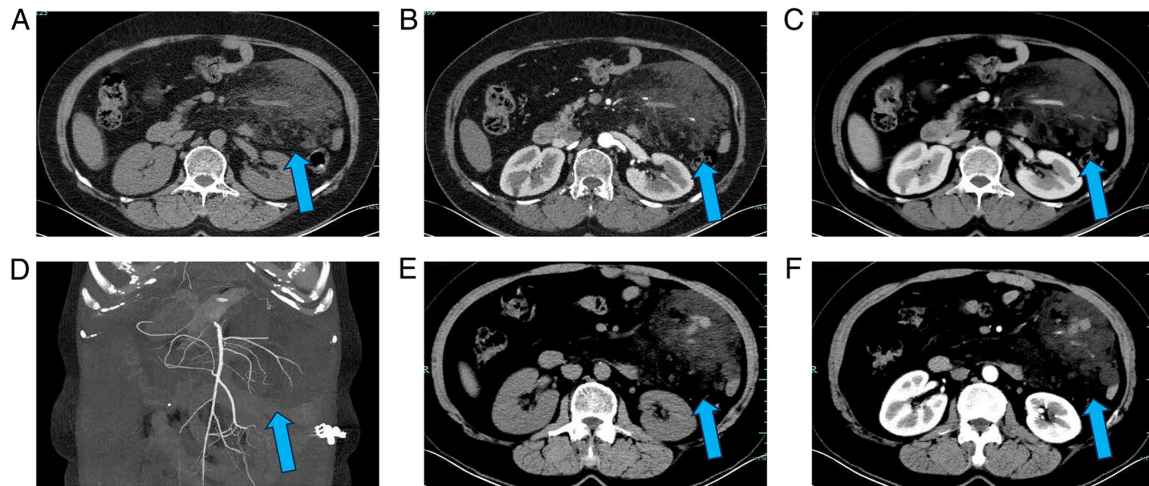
Serial contrast-enhanced CT findings of mesenteric cavernous lymphangioma. (A-D) Initial CT examination performed at admission. (A) Non-enhanced CT image demonstrating an irregular, well-defined, low-attenuation mass in the left middle abdomen (blue arrow). (B) Arterial phase CT image showing no notable enhancement of the lesion, with mesenteric vessels traversing through the mass (blue arrow). (C) Portal venous phase CT image demonstrating persistent absence of significant enhancement within the lesion, with preservation of the traversing mesenteric vessels (blue arrow). (D) MIP reconstruction image demonstrating the vessels passing through the lesion (blue arrow). (E and F) Follow-up contrast-enhanced CT performed 7 days after admission. (E) Non-enhanced CT image showing newly developed hyperattenuating foci within the lesion, suggesting intralesional hemorrhage (blue arrow). (F) Contrast-enhanced CT image demonstrating persistent absence of notable enhancement within the lesion, with the hemorrhagic components remaining visible (blue arrow). CT, computed tomography; MIP, maximum intensity projection.
